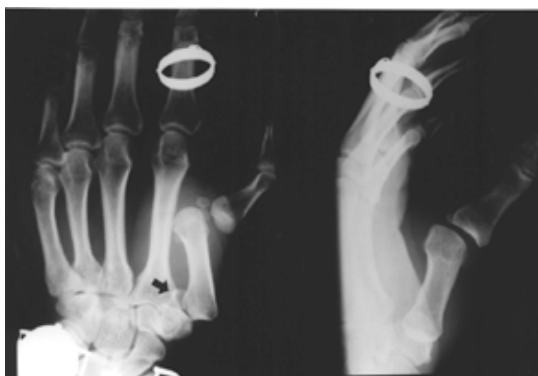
Initial X-ray shows simultaneous dislocation of the metacarpophalangeal and carpometacarpal joint. Chip bone fracture of the 1st metacarpal base is also seen (arrow).
